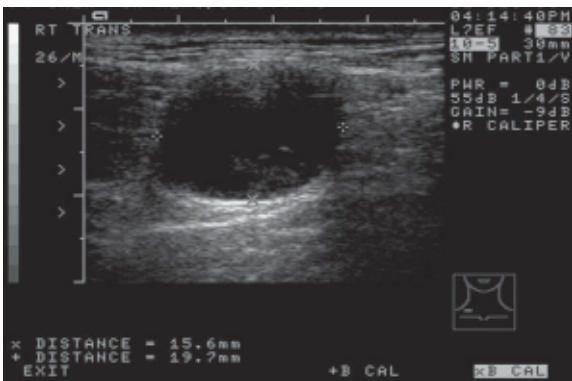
Ultrasound of patient CFM showing a 19.7 x 15.6 mm right supraclavicular non-vascular well-defined cystic lesion containing dependant debris. This was diagnosed intraoperatively as an accessory nerve schwannoma.
